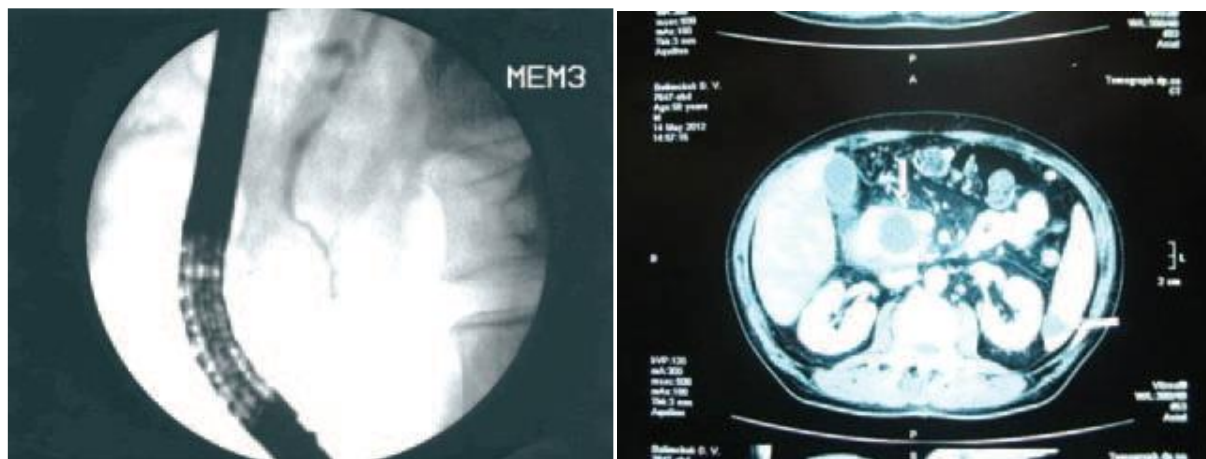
on the left a) ERCP, virsungodilatation with segmental obstruction in a patient with pancreatic pseudocyst; right b) CT of the same patient with a cyst of the pancreatic head
